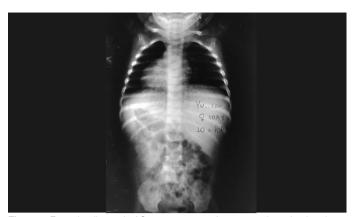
Frontal radiographof Case 1,10 years after surgery (post-laminoplasty, durotomy, and drainage).
